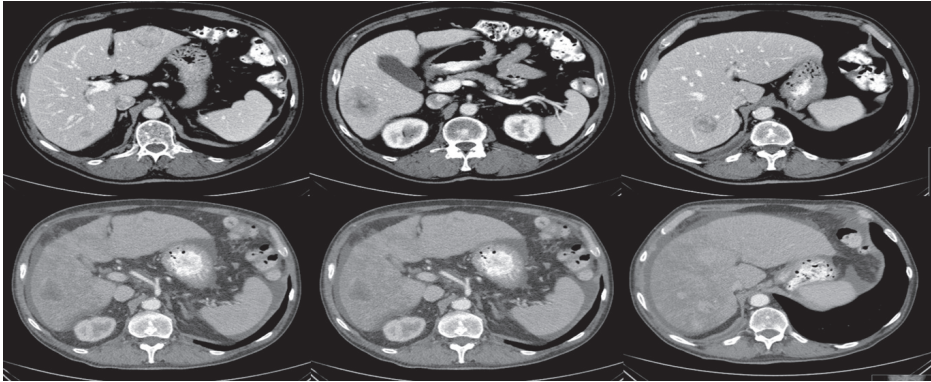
The upper row shows contrast-enhanced CT images of a 60-year-old woman with hepatic metastases of a neuro-endocrine carcinoma, before treatment with radioembolization. The lower row shows contrast-enhanced CT images after treatment with ^{166}Ho -radioembolization, with the development of REILD (impaired hepatic function and ascites).
